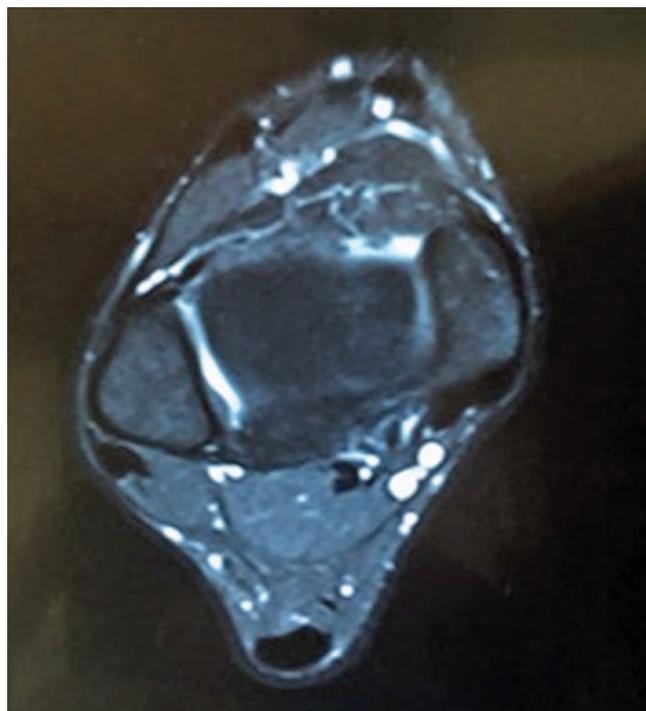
Ankle magnetic resonance imaging in axial position showing the lateral ligament injury.
